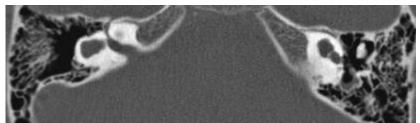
Axial CT image depicting globose dilatation of the vestibule with partial or complete assimilation of the semicircular canals into the vestibule.
